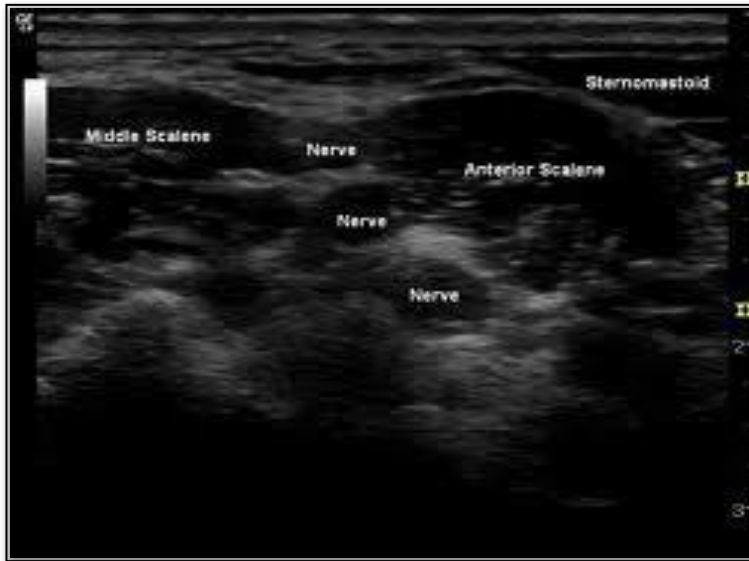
Showing nerves and muscles on Ultrasonographic image.
